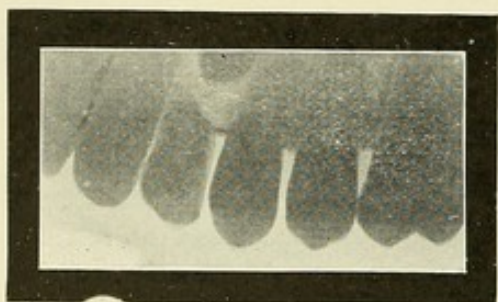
X-ray in dentistry. Permanent tooth showing under milk tooth.
